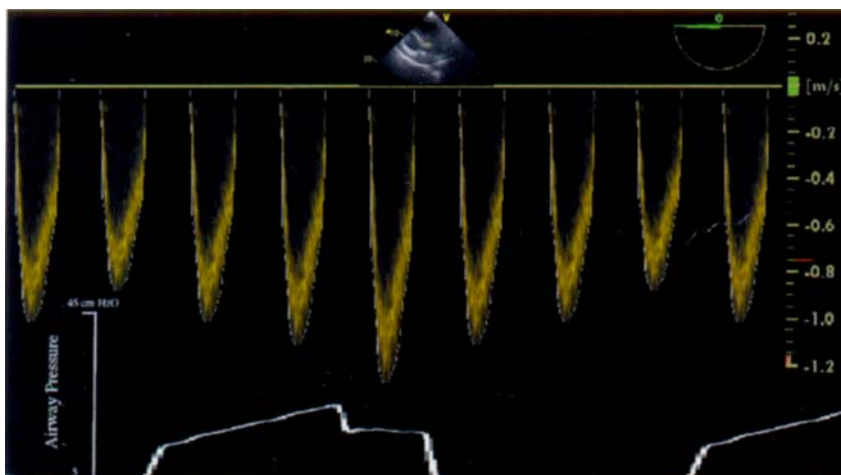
Cyclic respiratory changes in airway pressure and in aortic Doppler velocity. Beat-to-beat measurement of the aortic velocity–time integral (VTI_{Ao}) allows determination of $VTI_{Ao,max}$ and $VTI_{Ao,min}$ over a single respiratory cycle. The ΔVTI_{Ao} is then calculated as the difference between $VTI_{Ao,max}$ and $VTI_{Ao,min}$ divided by the mean of the two values and is expressed as a percentage.
